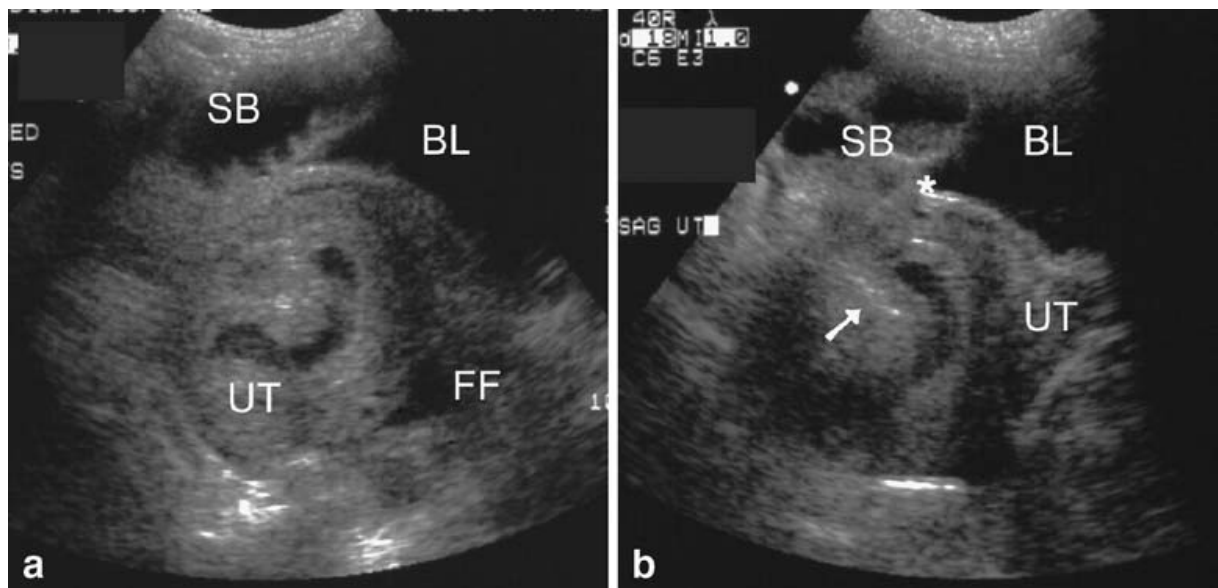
Transvaginal pelvic ultrasound transversely demonstrates multiple tubular structures containing anechoic fluid within the uterine cavity (UT). Sagittally, echogenic material (arrowheads), suggesting the presence of fat, is adjacent to the intrauterine tubular structure [47]
